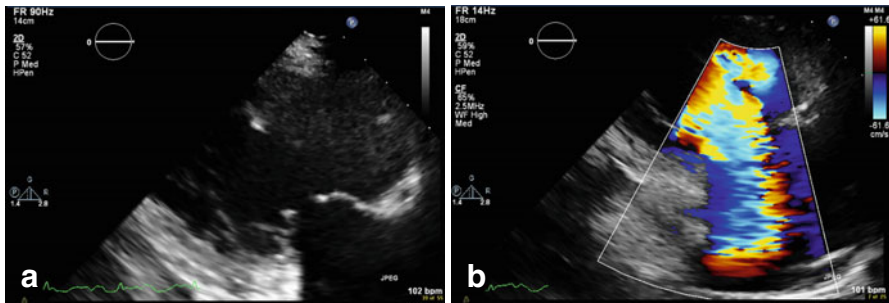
(a, b) Case echocardiograms. (a) 2-dimensional echocardiogram of the tricuspid valve in systole showing significant leaflet separation (malcoaptation) in systole. (b) Color-Doppler echocardiogram in the same projection showing severe tricuspid regurgitation through the separated valve leaflets
